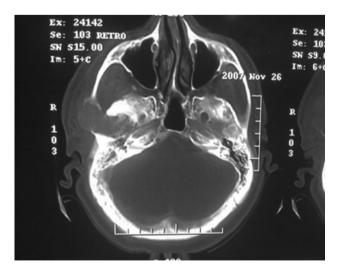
Infratemporal lesion before the first surgery (axial view of CT scan with IV contrast)
